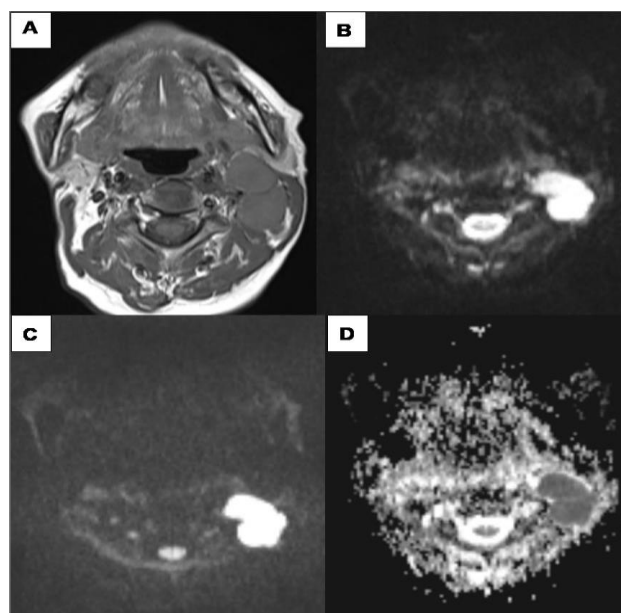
NHL. Axial T1W MR image (A) showing multiple enlarged left level II lymph nodes with homogeneously low SI. Enlarged lymph nodes show high SI on DW-MRI image at $b=0$ s/mm² (B) and $b=1,000$ s/mm² (C). Enlarged lymph nodes shows low SI on ADC map (D). The mean ADC value of the left level II lymph node is $0.65 \pm 0.11 \times 10^{-3}$ mm²/s
